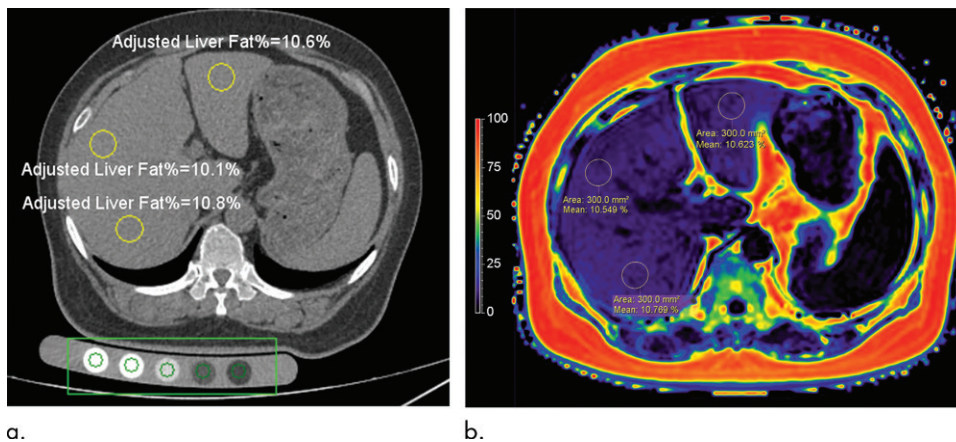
Liver fat content measurement with (a) quantitative CT and (b) chemical shift–encoded MRI in a 57-year-old woman. Three regions of interest (ROIs) were placed in the peripheral areas of the left lobe, right anterior lobe, and right posterior lobe of the liver, and the average of the three ROIs was chosen for the liver fat content.
